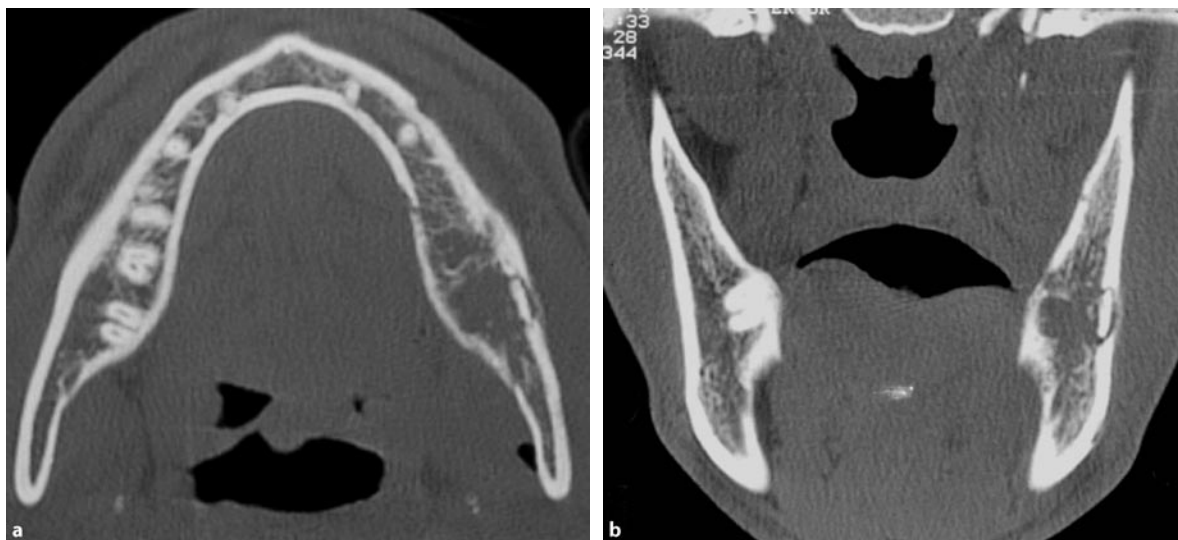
Advanced-stage acute osteomyelitis with involucrum formation and pathological fracture: a 23-year-old patient presents with sudden onset of pain and reduced mouth opening 2.5 weeks after drainage of a submandibular abscess, 4 weeks following extraction of 36 and 37. Axial (a) and coronal (b) high-resolution bone-window CT images depict an osteolytic area adjacent to empty tooth socket 37. Demineralization of lingual cortical
